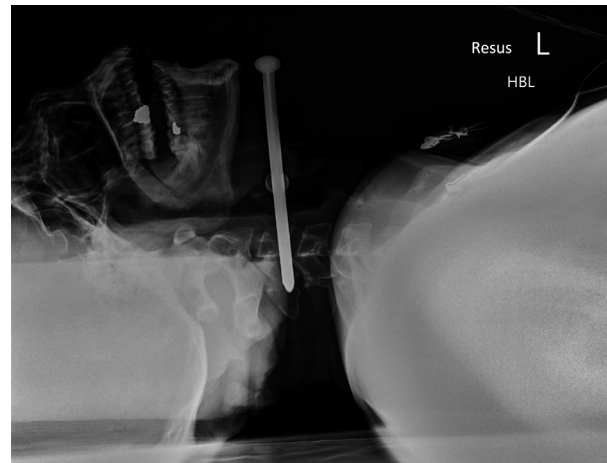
Lateral plain film X-ray confirming position of nail within the spinal column.
